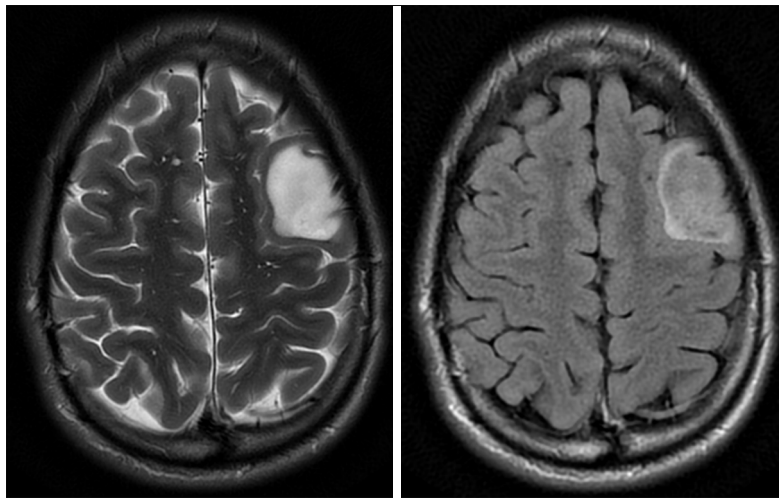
Axial T2 (left) and FLAIR (right) images of a left frontal glioma demonstrating the T2-FLAIR mismatch sign, characteristic of an IDH^{mut} astrocytoma (1p/19q-non-codeleted). The signal is substantially lower on the FLAIR sequence compared to T2. FLAIR, fluid-attenuated inversion recovery; IDH^{mut}, IDH-mutant; IDH, isocitrate dehydrogenase.
